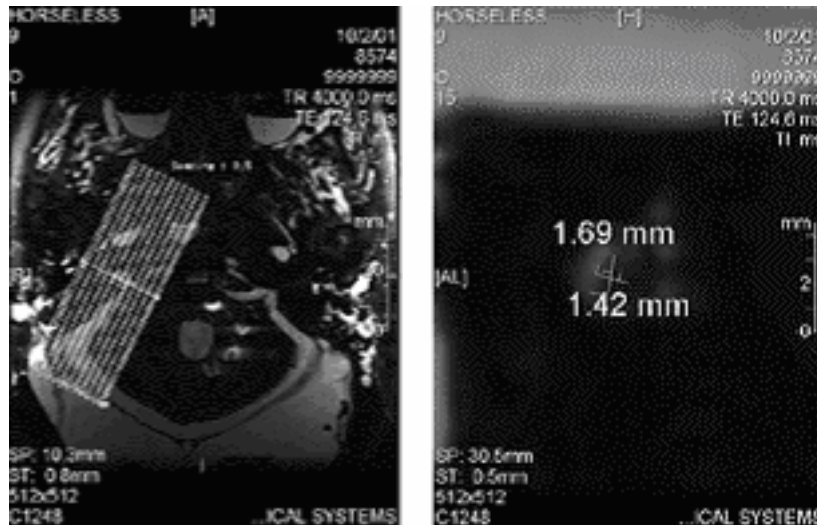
MRI sagittal section of the internal auditory meatus using the FIESTA sequence.
